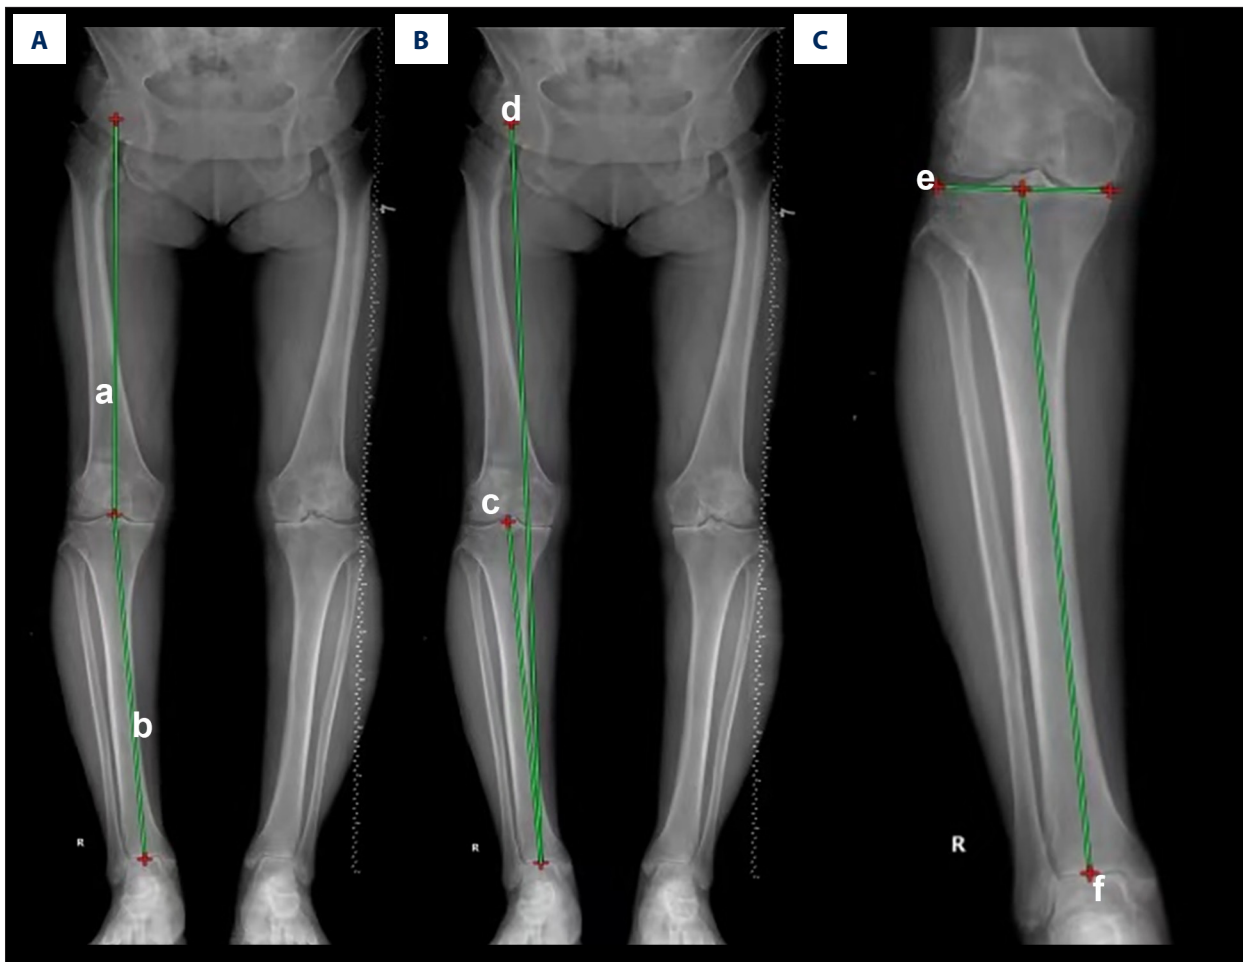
Measurement of hip-knee-ankle angle (HKA) and ankle parameters based on full-leg standing anteroposterior radiographs. HKA was defined as the medial angle between (a) and (b) (A). Lateral tibial angle was defined as the medial angle between (c) and (d) (B). Medial angle of the proximal tibia was defined as the lateral angle between (d) and (f) (C).
